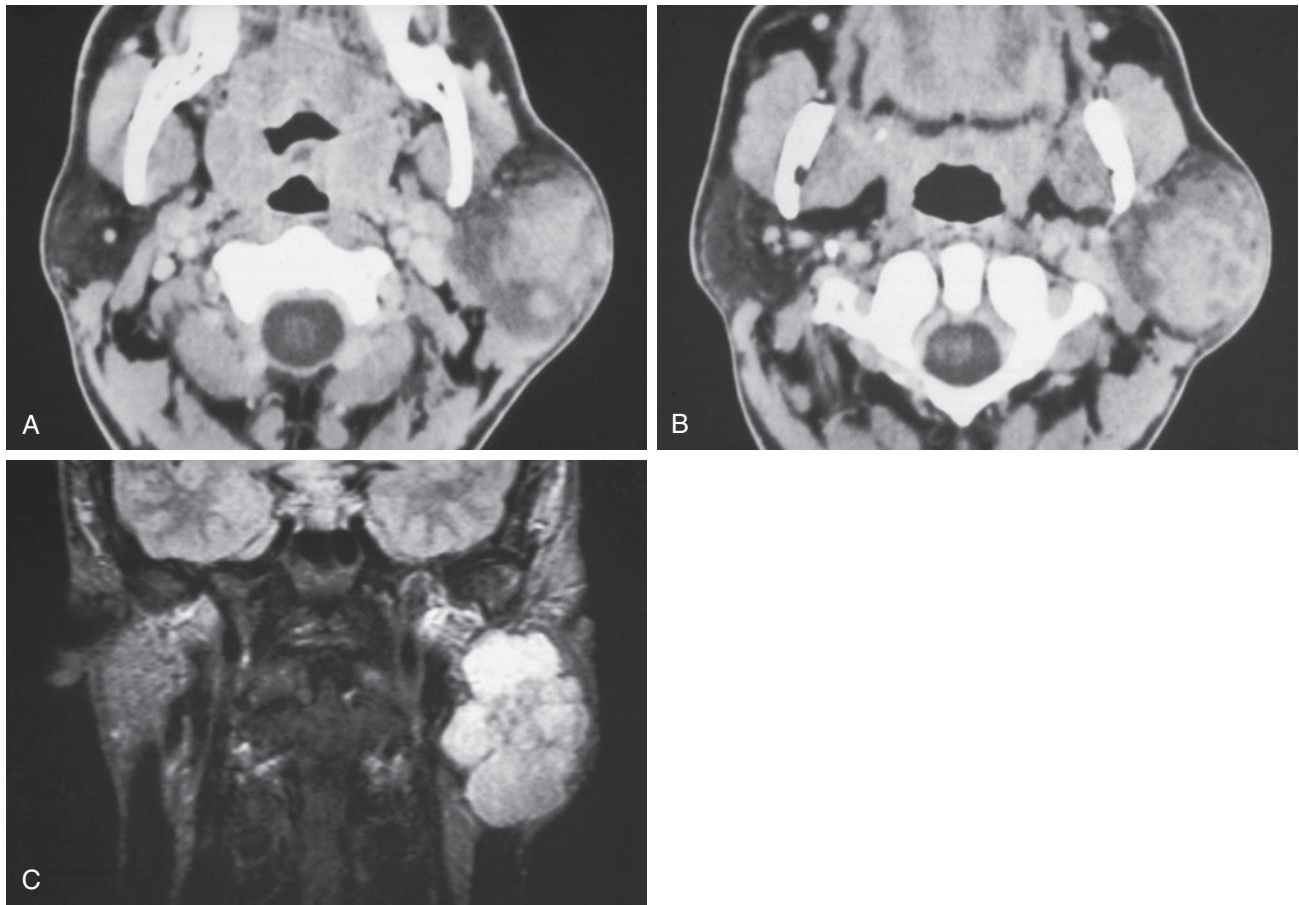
CT and MR of pleomorphic adenoma.
